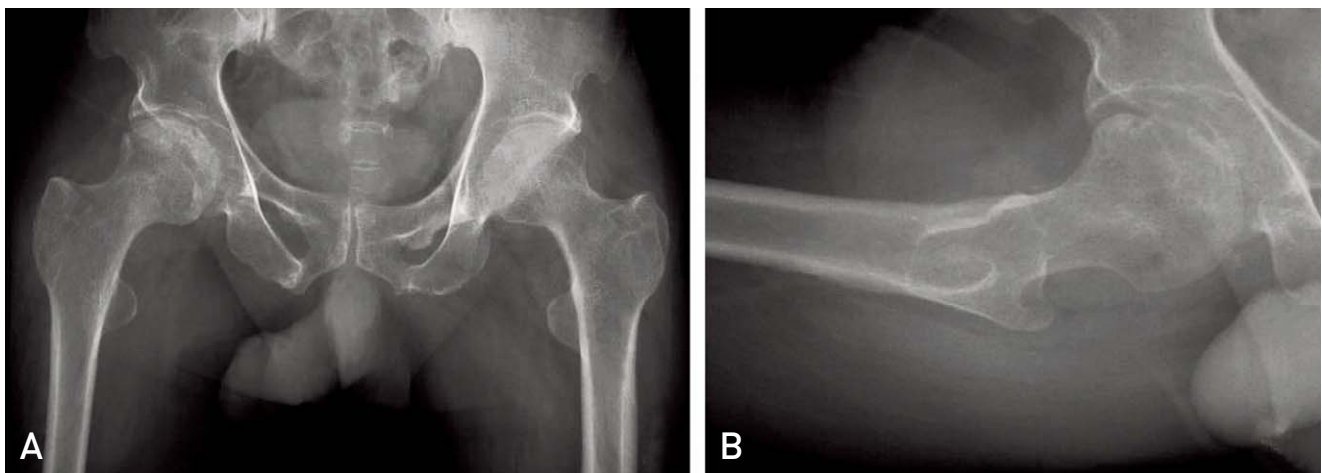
(A) Preoperative anteroposterior radiograph of both hips showing the crescent sign and sclerotic lesions of the right femoral head. The pelvis was mildly distorted and both proximal femurs were deformed (hip medullary canals were narrow and neck shaft angles were high). (B) Lateral radiograph of the right hip showing the crescent sign on the anterior part of the femoral head.
